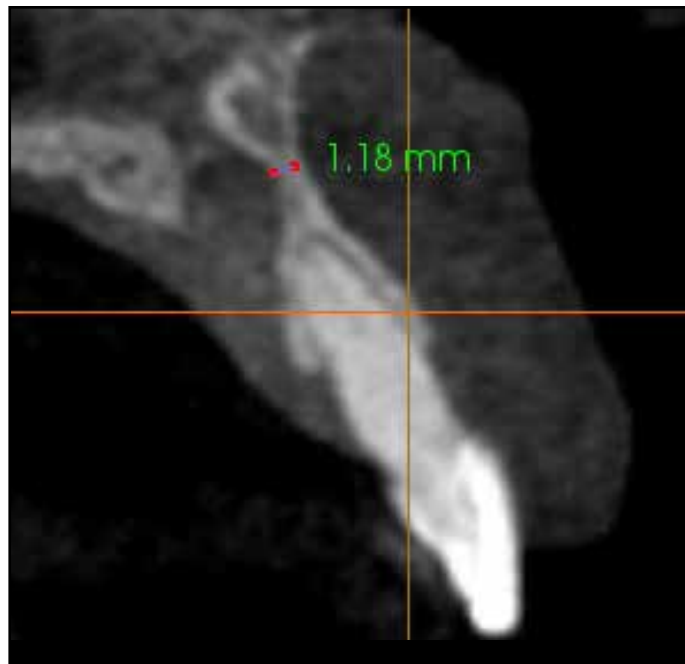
Presurgical CBCT scan showing minimal bone thickness in the maxillary anterior sextant.
